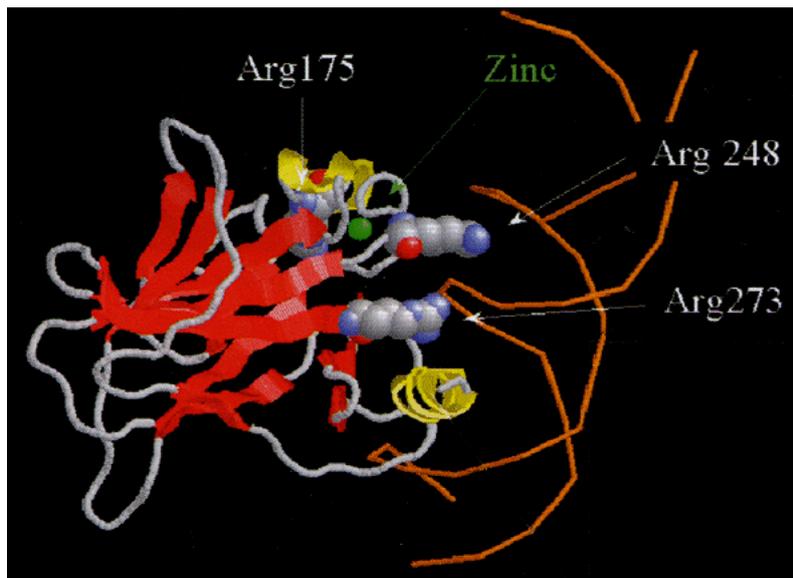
Three-Dimensional Representation Of The p53 Protein Structure In Its Isomorph Form, Obtained Through X-ray Imaging. In Hereditary Cancer Clinics, Five Mutations Of The P53 Gene Have Been Identified, (Okorokov AL, Sherman MB, Plisson C, et al. The Structure Of p53 Tumour Suppressor Protein Reveals The Basis For Its Functional Plasticity, 2006, APC Journal).
